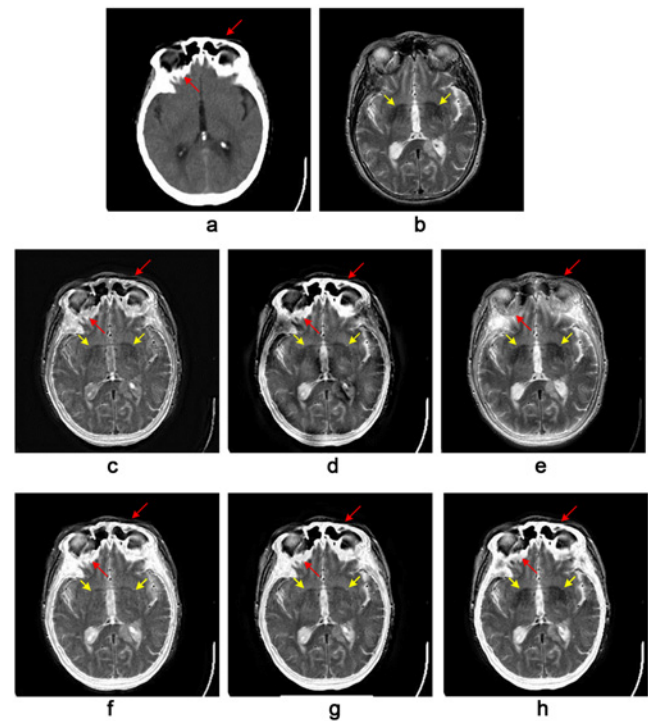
(a) CT image, (b) MRI image, fused image by (c) M1 [22], (d) M2 [19], (e) M3 [27], (f) M4 [23], (g) M5 [20], and (h) M6.
